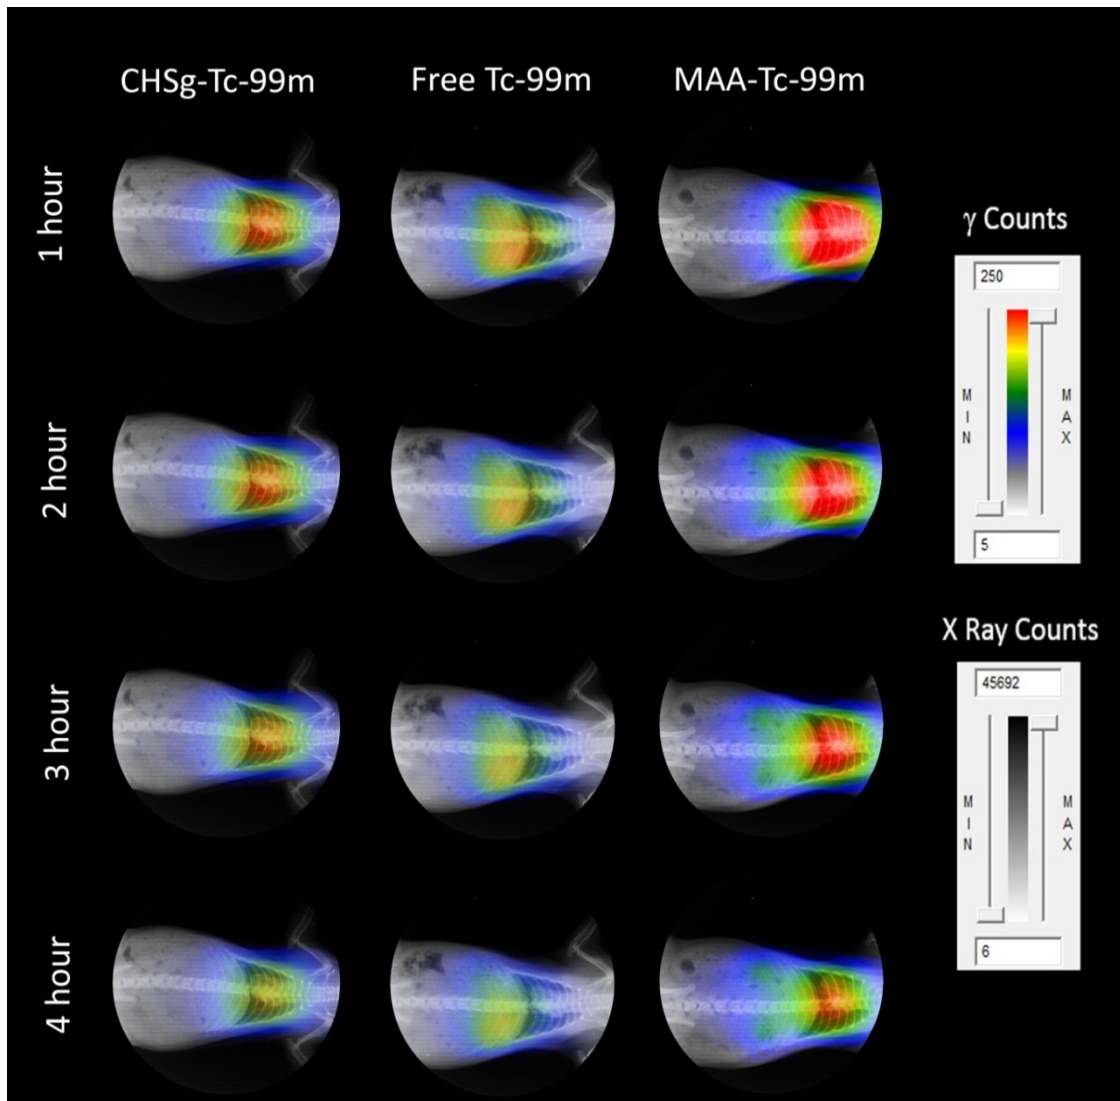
Un-collimated, non-decay-corrected full body X-Ray/Autoradiography of ^{99m}Tc -CHSg, ^{99m}Tc -MAA and free ^{99m}Tc .
